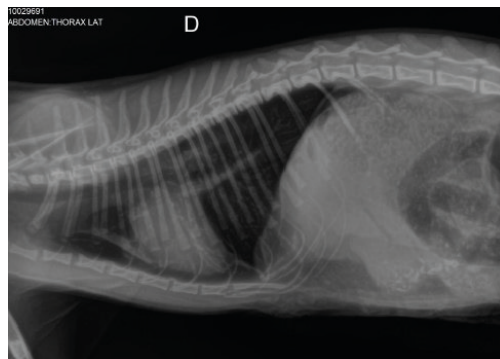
Postoperative X-ray showing well-defined diaphragmatic dome.
